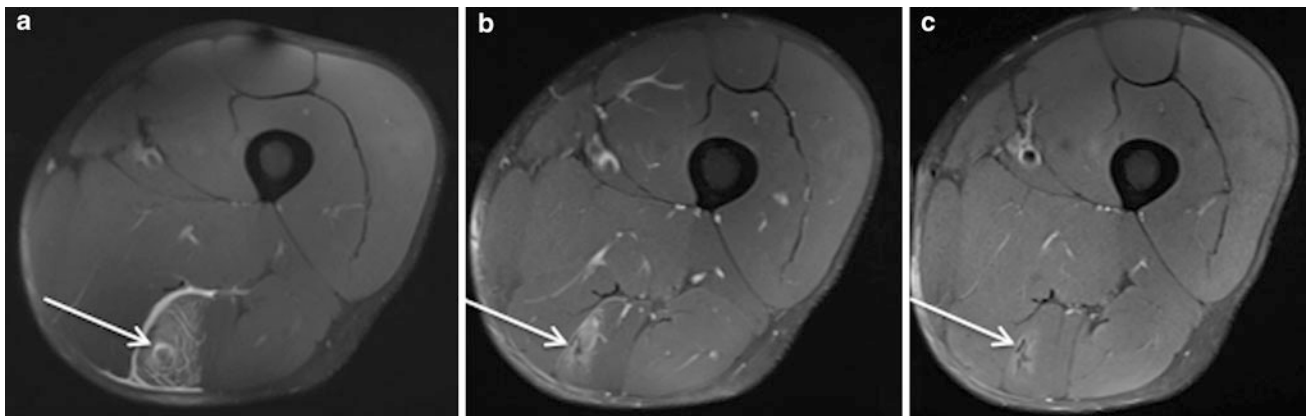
Axial proton density weighted MR images with fat saturation (a–c) in a professional rugby league player. a Shows an acute semitendinosus muscle–tendon junction injury the day after the injury occurred, the *arrow* indicating a small focus of muscle fibre discontinuity, with surrounding feathery intramuscular oedema and thin layer
